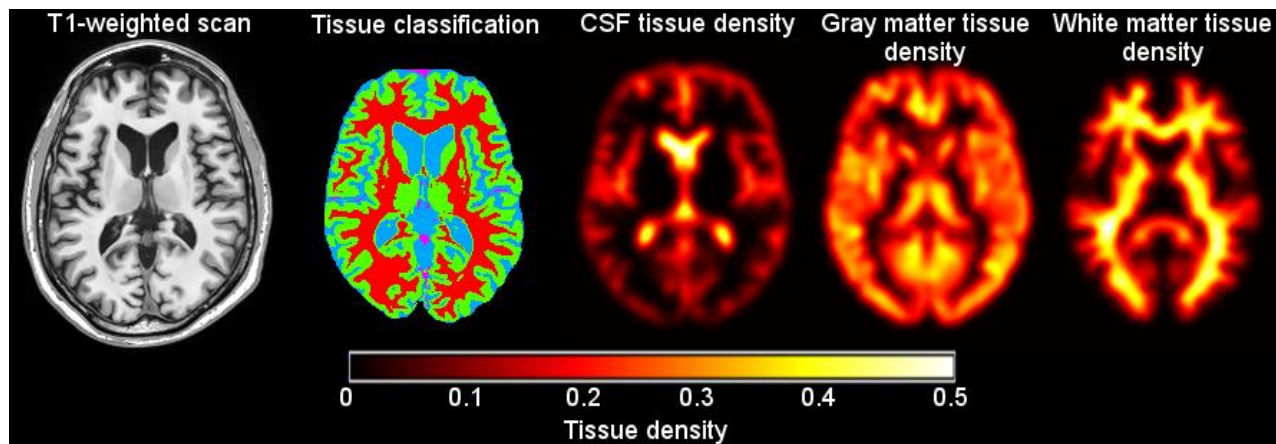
Example of VBM maps. The T1-weighted scan (leftmost) is segmented by tissue type (second image from the left; white matter (red), gray matter (green) and CSF (blue)). Each tissue type is smoothed with an isotropic Gaussian kernel (8 mm full width half maximum in the example) resulting in the tissue density maps. Higher tissue density indicates greater concentration of the tissue.
